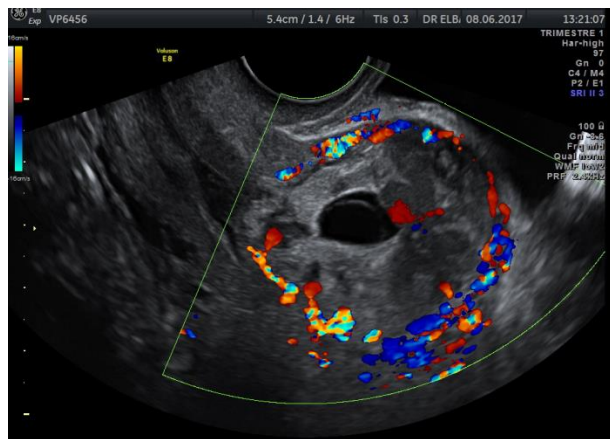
Sagittal section of the uterus with color Doppler window showing a gestational sac with invasion of the myometrium by the trophoblast at the scar
